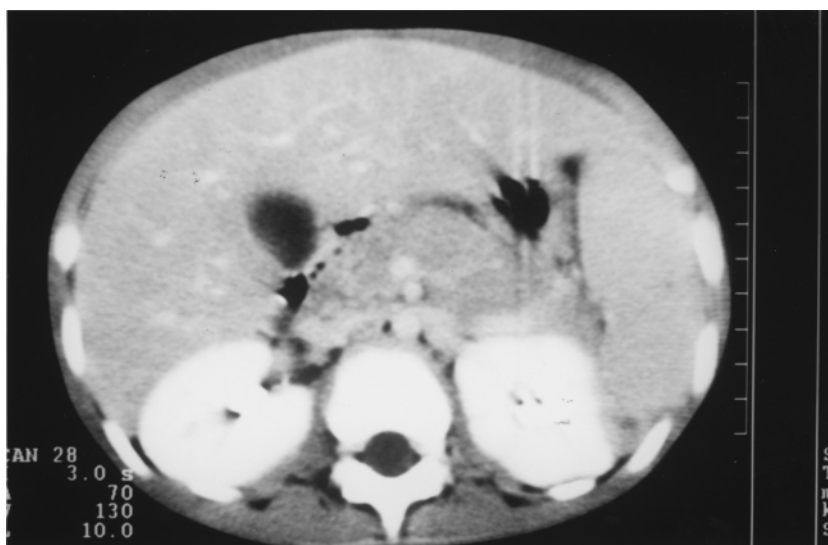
CT scan of abdomen with enlargement of lymph nodes and hepatosplenomegaly.
